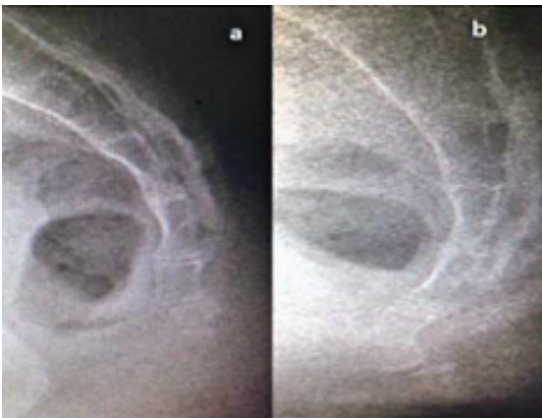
Dislocation of the distal posterior coccyx that is unevent in side coccyx radiography taken standing (a) is visible in radiography taken sitting (b)
